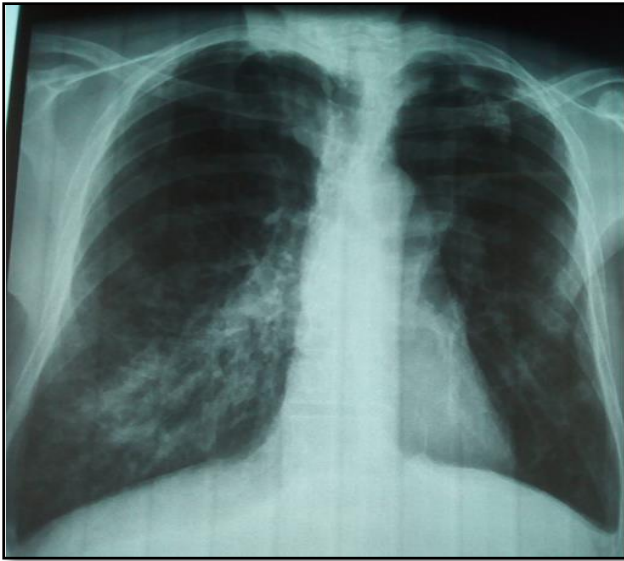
The chest X-ray showing the right basal pneumonia
